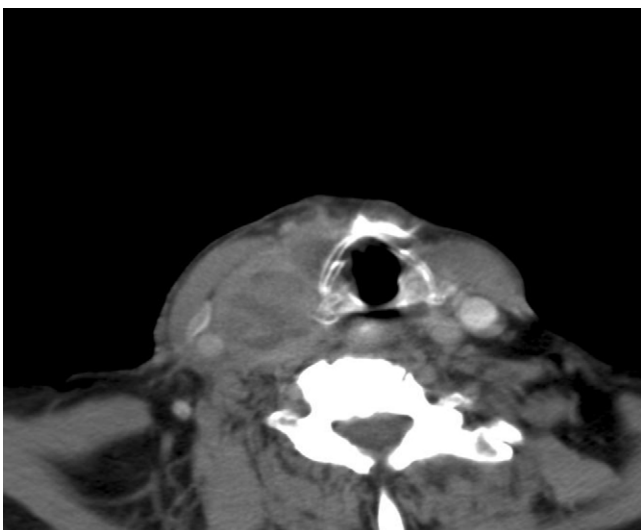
Cross-sectional CT image of the right neck mass.
